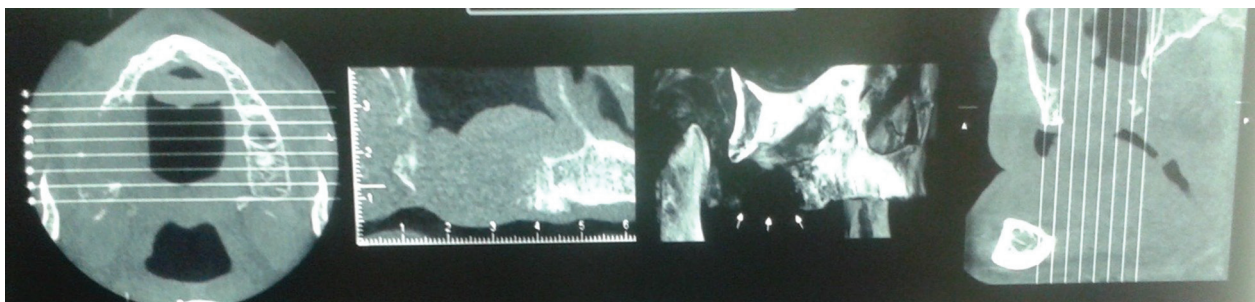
Cone beam computed tomography (CBCT) showing destruction of buccal and palatal plate of the maxillary bone.
